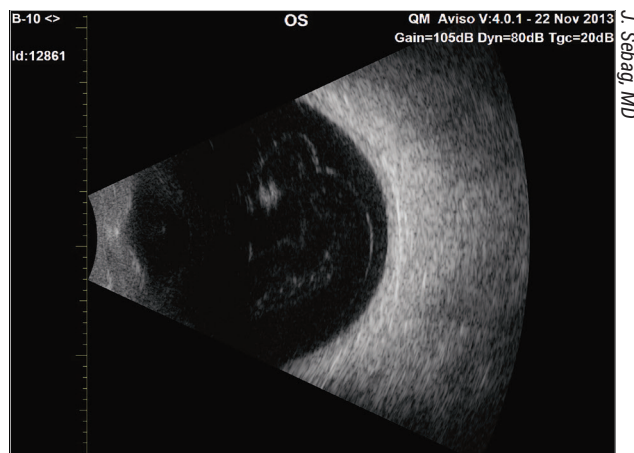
B-scan ultrasound demonstrates posterior vitreous detachment and central vitreous echodensities. Both interfere with photon transmission to the retina, resulting in degradation of contrast sensitivity from untoward light scattering.¹ The large echodensity towards the top of this image might be amenable to YAG laser vitreolysis, while the other densities and the posterior vitreous cortex are probably best treated by vitrectomy.
